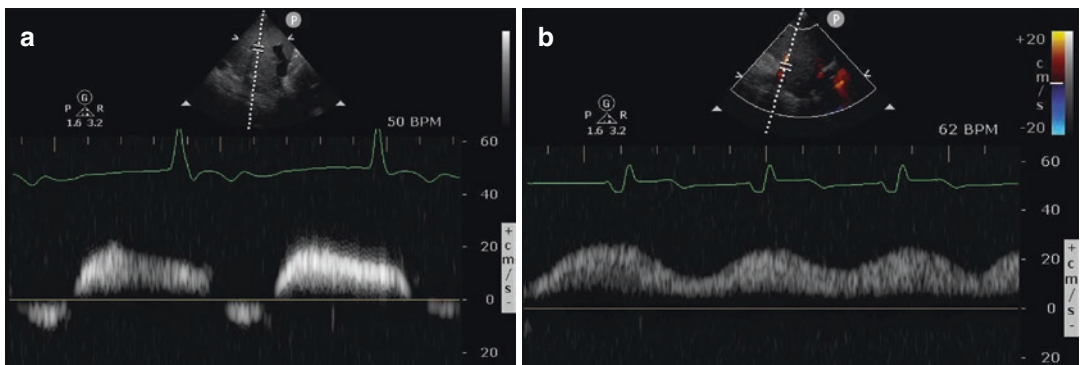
Doppler assessment of portal flow in an 80 years-old male patient admitted for decompensated congestive heart failure with severe left and right ventricular dysfunction (LVEF: 20%), severe pulmonary hypertension (systolic PAP: 65 mmHg), significant tricuspid regurgitation (Grade III/IV) and elevated NT-Pro-BNP
